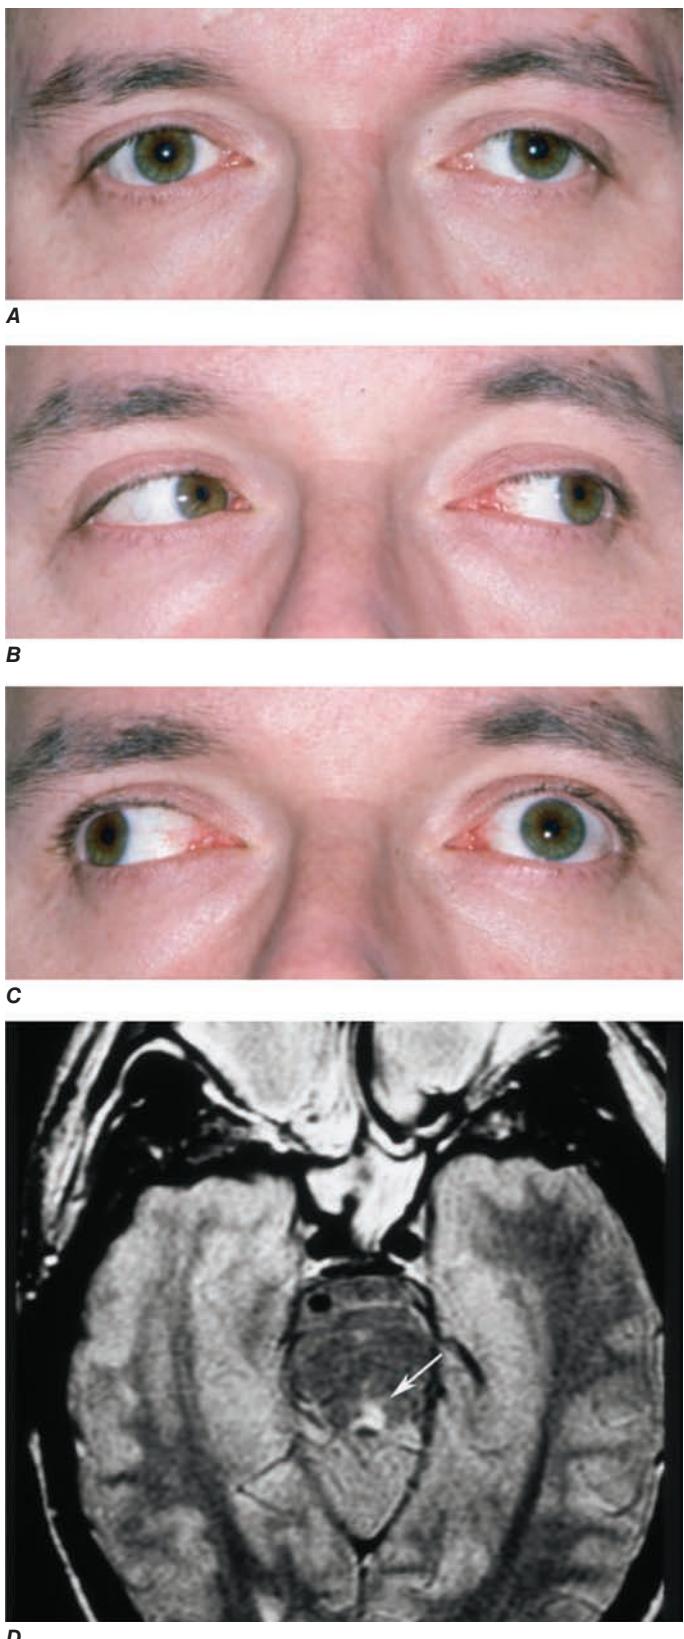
Left internuclear ophthalmoplegia (INO). A. In primary position of gaze, the eyes appear normal. B. Horizontal gaze to the left is intact. C. On attempted horizontal gaze to the right, the left eye fails to adduct. In mildly affected patients, the eye may adduct partially or more slowly than normal. Nystagmus is usually present in the abducted eye. D. T2-weighted axial magnetic resonance image through the pons showing a demyelinating plaque in the left medial longitudinal fasciculus (arrow).
